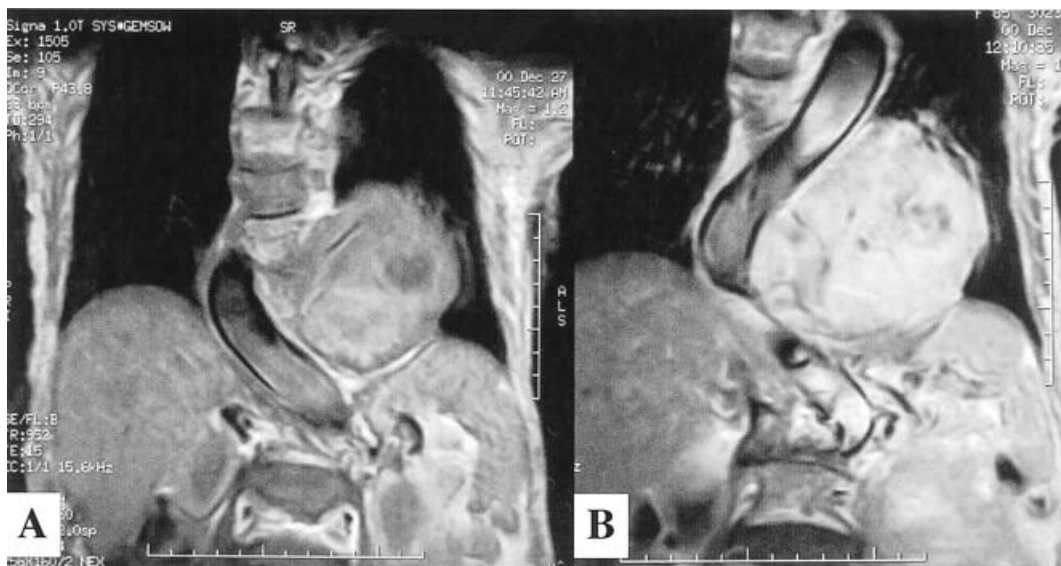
The findings of the magnetic resonant imaging. Fig. 3A is the T1-weighted image and Fig. 3B is the T2-weighted image.
